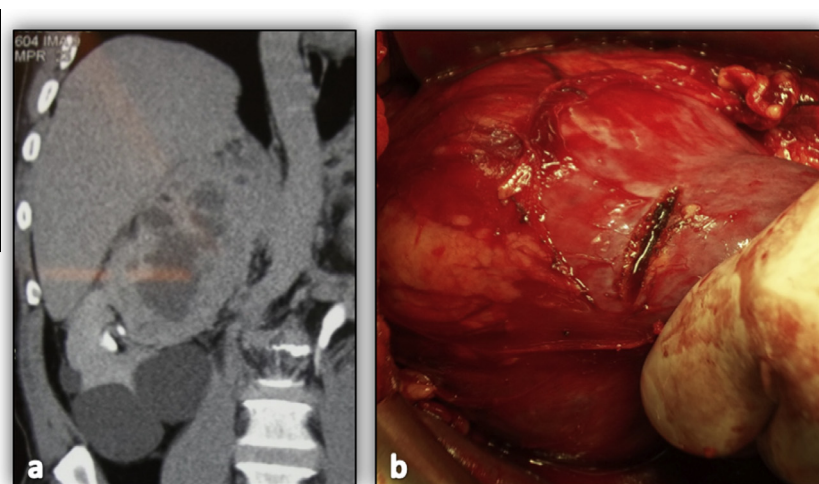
Coronal CT image of a right renal upper polar mass (a) and the corresponding intraoperative picture (b).
